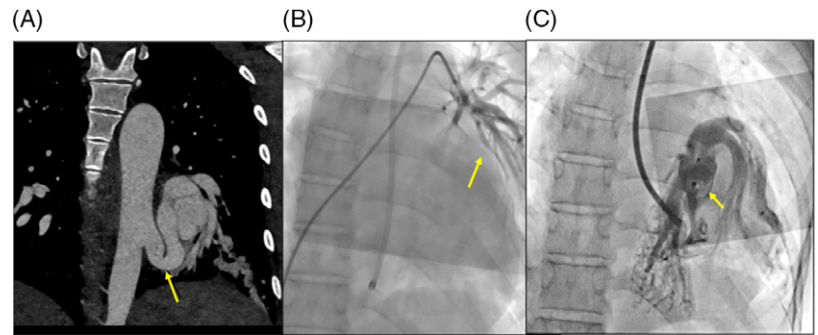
Panel A: CT angiogram in coronal section shows the anomalous artery (arrow) arising from descending thoracic aorta at the level of eighth thoracic vertebra and supplying all the basal segments of the left lower lobe. Panel B: Catheter angiogram in left pulmonary artery confirming intact pulmonary arterial supply to the corresponding lung segments (arrow). Panel C: Catheter angiogram soon after occlusion of the anomalous artery using vascular plug shows a well-positioned device in situ and mild residual flow through the device.
